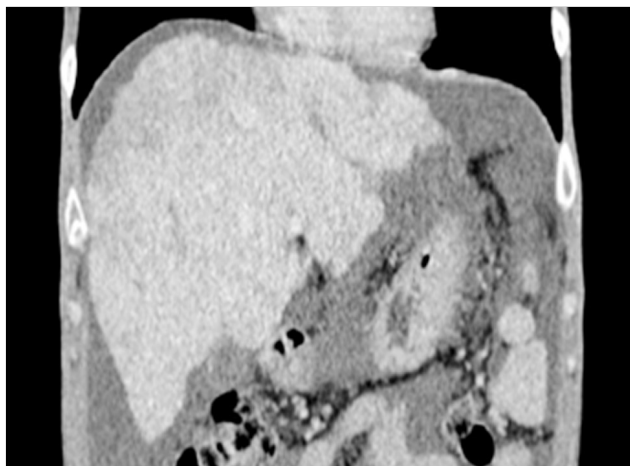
CT scan 1.5 mm coronal - Direct Intrahepatic Portocaval Shunt thrombosis (June 2018)
